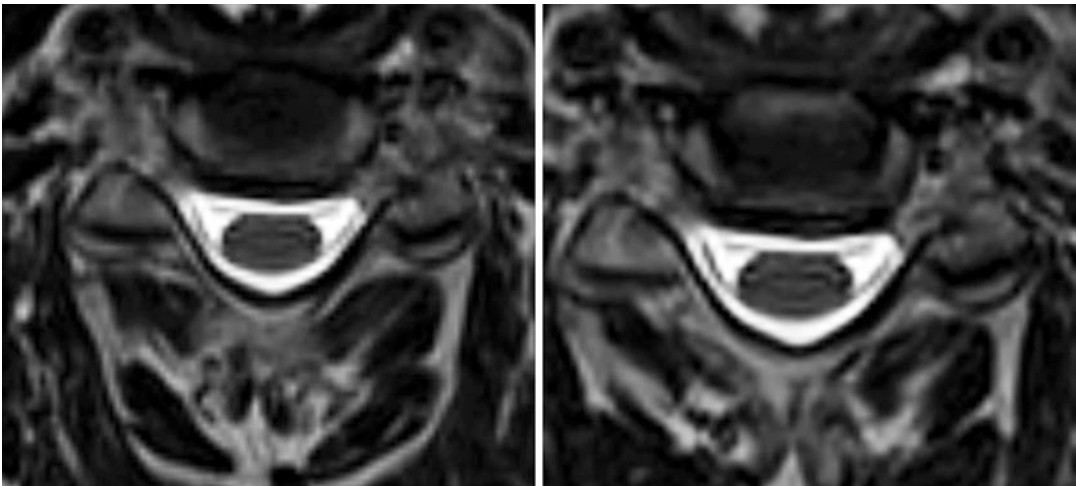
Potential for MRI in depicting nerve roots: nonconsecutive 2D-reformatted axial images from high-resolution 3D-TSE T2-weighted images. At C4-C5 (*left*
